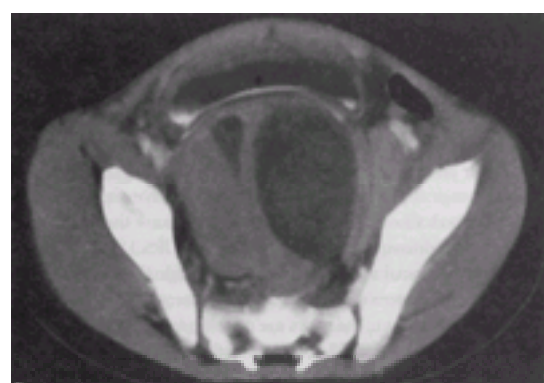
This 5-year-old boy presented with a 2-week history of leg pain and constipation and 1-day of dysuria. On physical exam, lower abdominal fullness was noted with a prerectal mass. Ultrasound and this CT scan revealed a large heterogeneous mass in the region of the prostate indenting the bladder base. The cystic area suggested necrosis. A cystoscopic biopsy confirmed the diagnosis of embryonal rhabdomyosarcoma.
